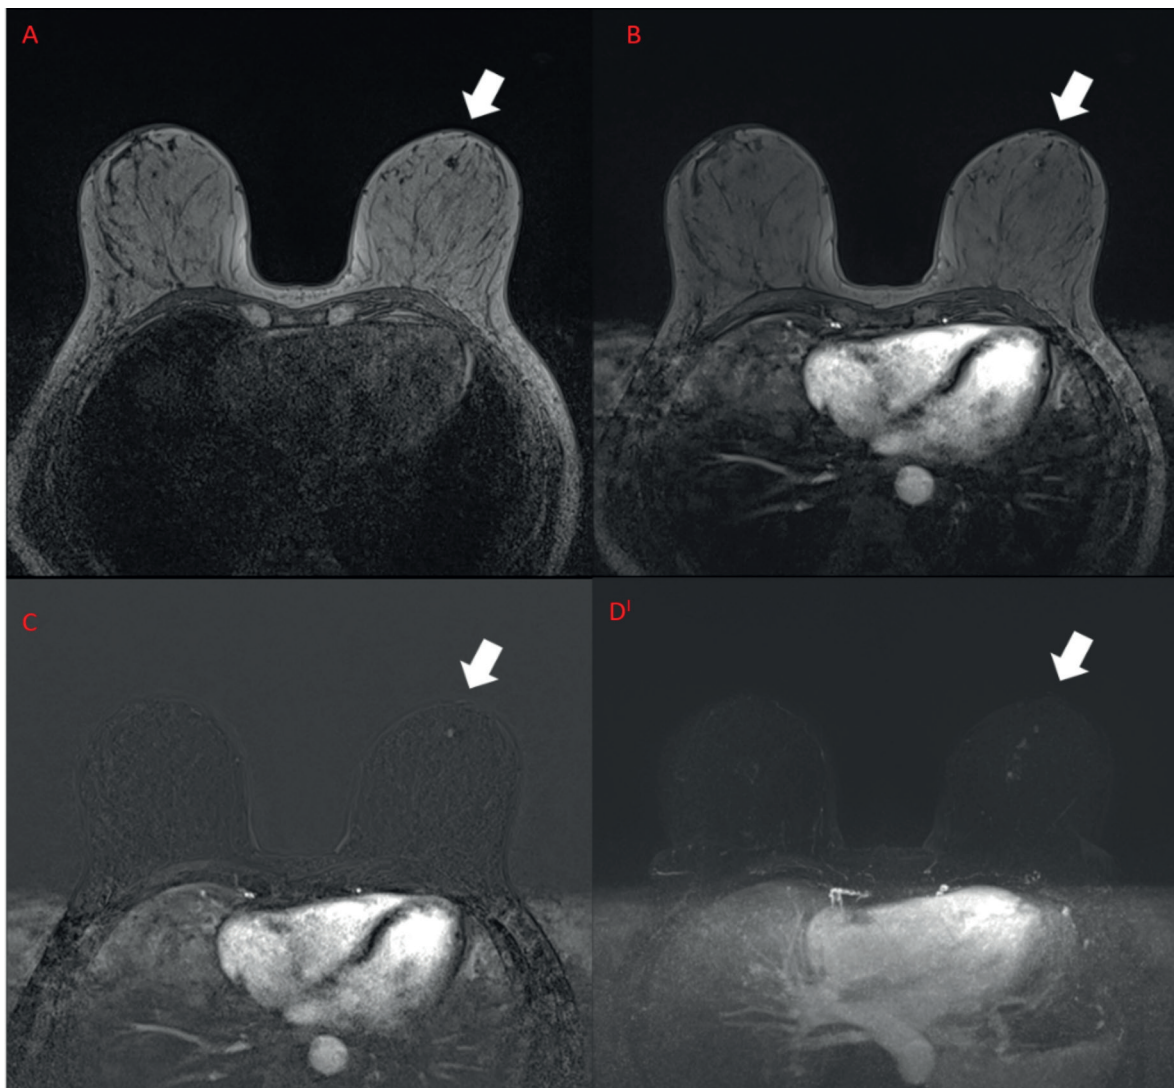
Abbreviated breast MRI protocol shows left lesion (A and B) with ce in early postcontrast T1 (C) and subtraction MIP sequences (D).
